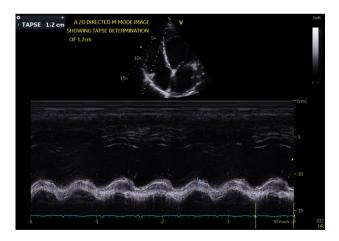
Echocardiographic image of one of the participants showing the 2D directed M-mode TAPSE of 1.2 cm measurement in the RV focused-apical four chamber view. TAPSE, tricuspid annular plane systolic excursion; M-mode, Motion mode; RV, right ventricle; HR, heart rate.
